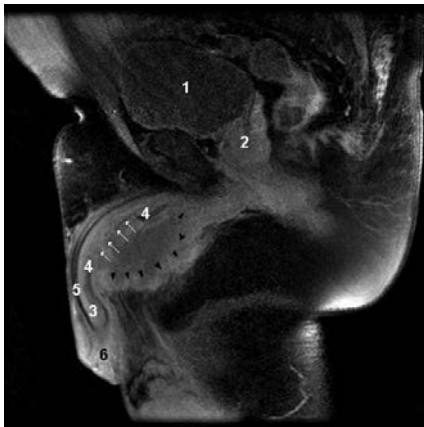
Axial T1-weighted magnetic resonance image showing the rupture of the tunica albuginea (white arrows) and expanding hematoma on the left base of the penis (black arrows). 1=bladder, 2=prostate, 3=corpus cavernosum, 4=tunica albuginea, 5=urethra, 6=glans penis.
